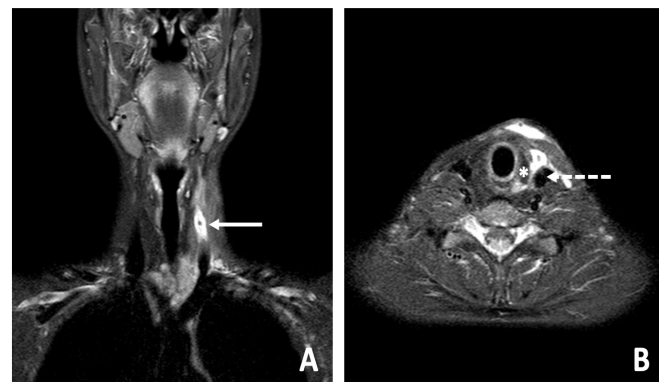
A) Cervical MRI, T2 sequence showing hyperintense fistulous tract with air content (solid arrow). B) Same image in axial plane projection. Anatomical relations of the fistula in proximity to the left thyroid lobe (asterisk) and the carotid sheath (dashed arrow).
